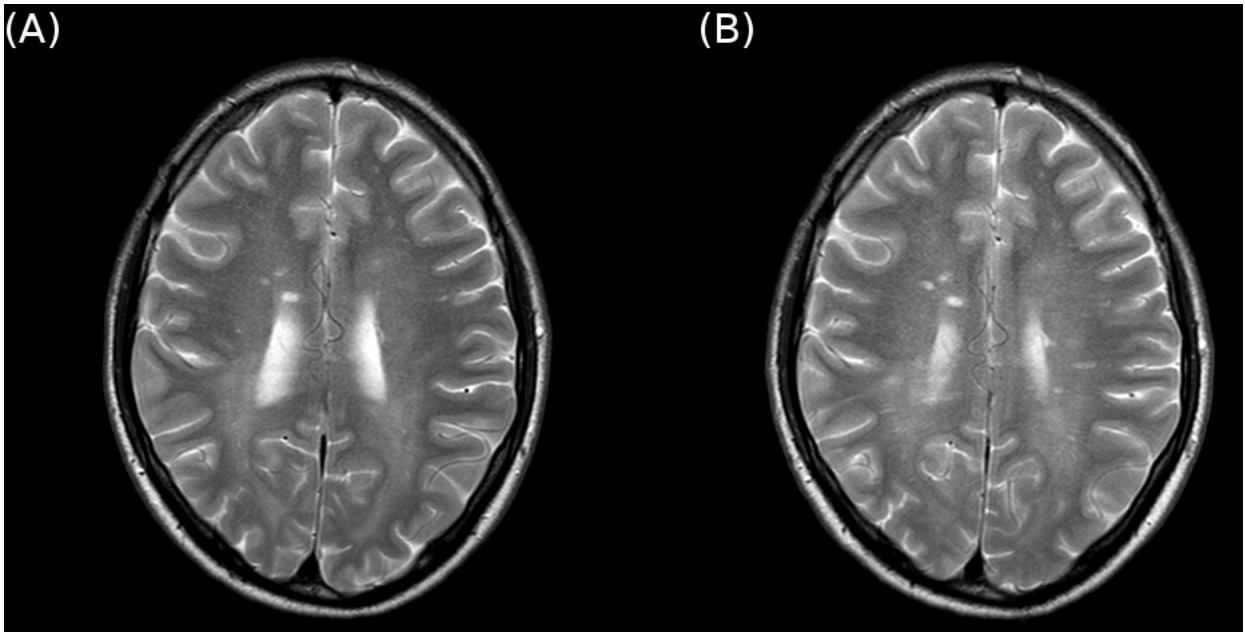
MRI brain of a 41 year-old man demonstrating non-contrast enhancing T-2 lesions exclusively located in the paraventricular regions in (A) April 2011 and (B) July 2011.*
